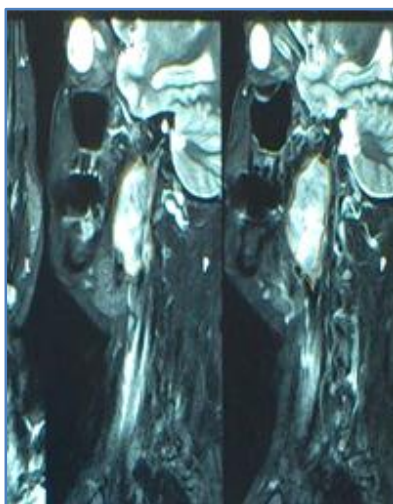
Showing CT scan Neck (Sagittal view) The Lower Extent of the tumor
